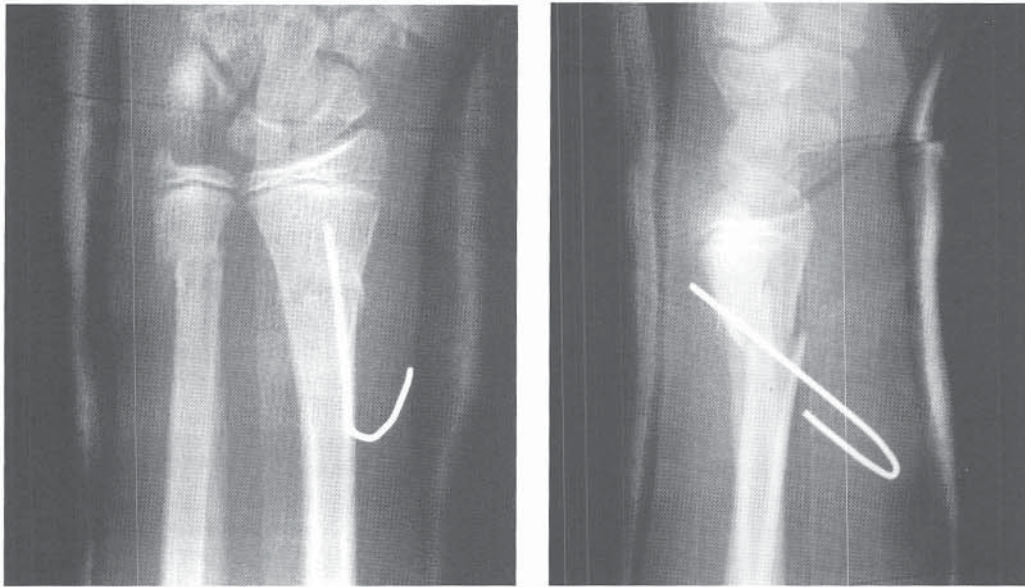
AP and lateral radiographs of an open distal both-bone forearm metaphyseal fracture that was treated with irrigation, debridement, and percutaneous pinning of the radius. Pin fixation allows the wound to be checked through a window in the cast without concern over loss of reduction.
